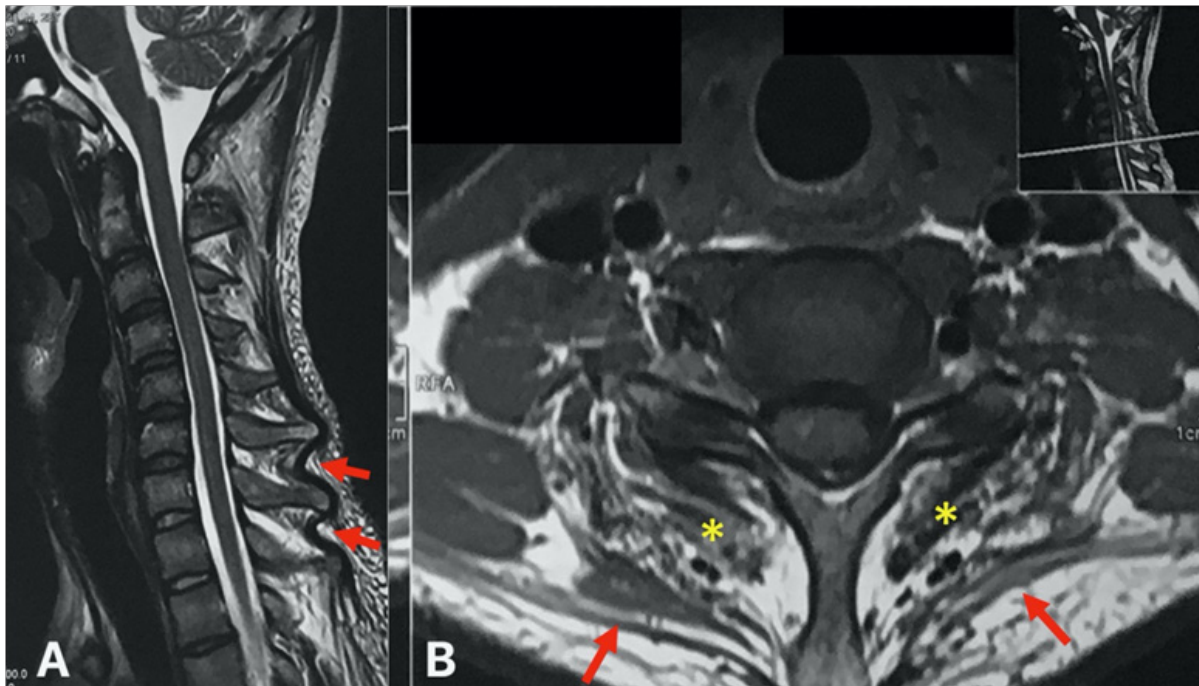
MRI findings: T2 weighted sagittal MRI of this patient revealed the sagging sign of the nuchal ligament (red arrows) (A) and T1 weighted axial MRI revealed fatty infiltration of the cervical multifidus (yellow asterisks) and trapezius (red arrows). Note that the trapezius became a thin line due to muscle dystrophy.
